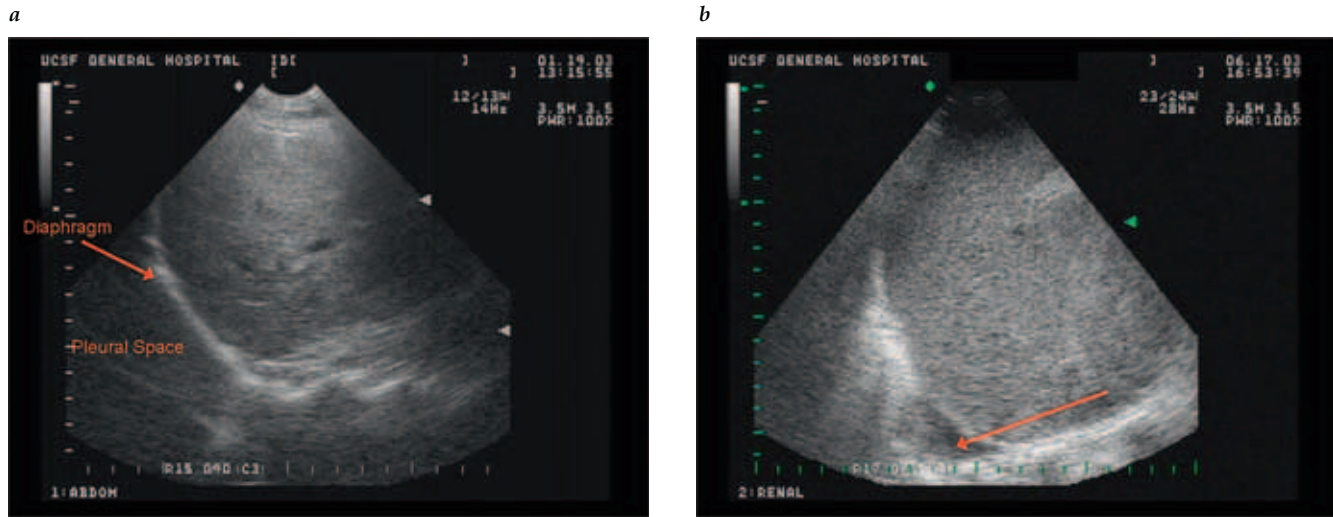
(a) Normal ultrasound view of the pleural space (arrow at diaphragm). (b) Ultrasound view of a hemothorax (arrow).
